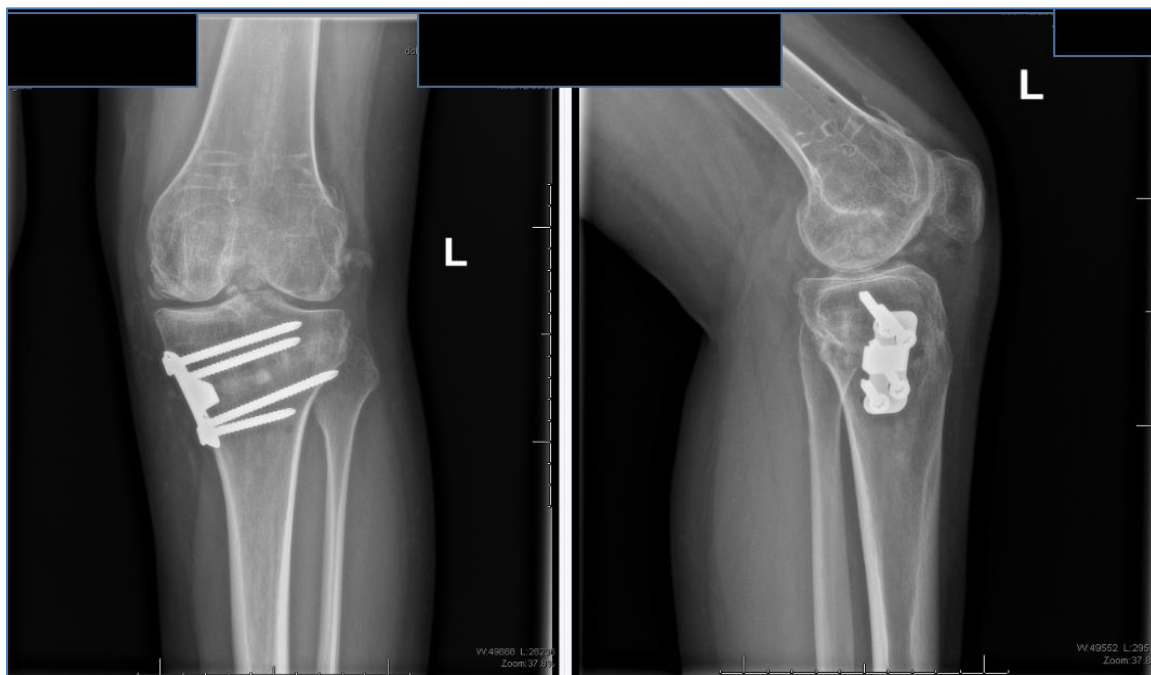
Final post-operative A/P and lateral knee radiographs that demonstrate removal of retrograde femoral nail, removal intercondylar H.O., and proper joint space alignment following proximal tibial osteotomy and lateral epicondylar osteotomy.
